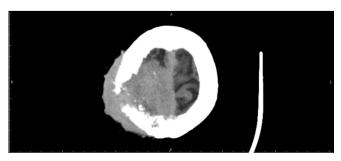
Brain CT scan showing tumor caused by bony erosion.
